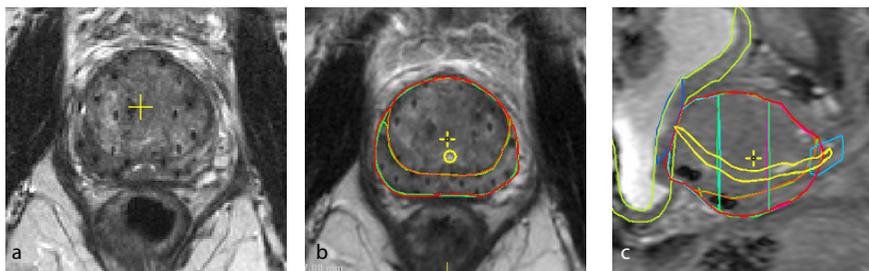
Contouring example, showing the delineated structures on magnetic resonance imaging (MRI). (a) Transversal slice of T2-weighted image. (b) Same transversal slice including contours. (c) Sagittal view. Delineation: red = prostate (target volume); yellow = urethra; orange = transition zone; green = peripheral zone; blue = lower sphincter; dark blue = bladder neck; light green = bladder muscle. In figure c, the separation in three equal thirds is seen, representing the apex, midprostate and base.
